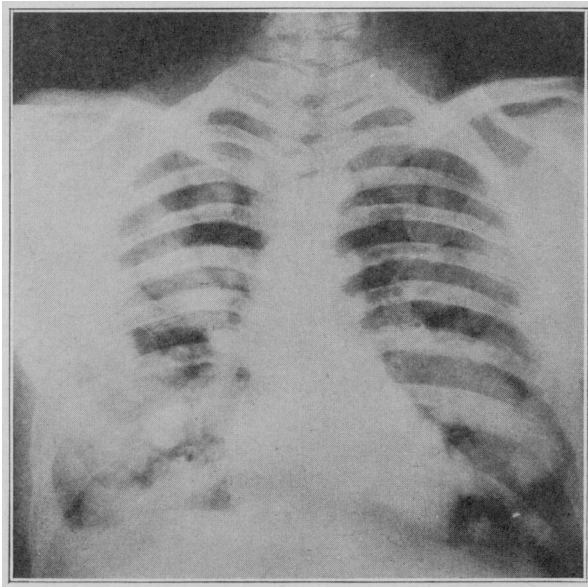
Roentgenogram of the chest, showing multiple nodular metastases to both lungs.
